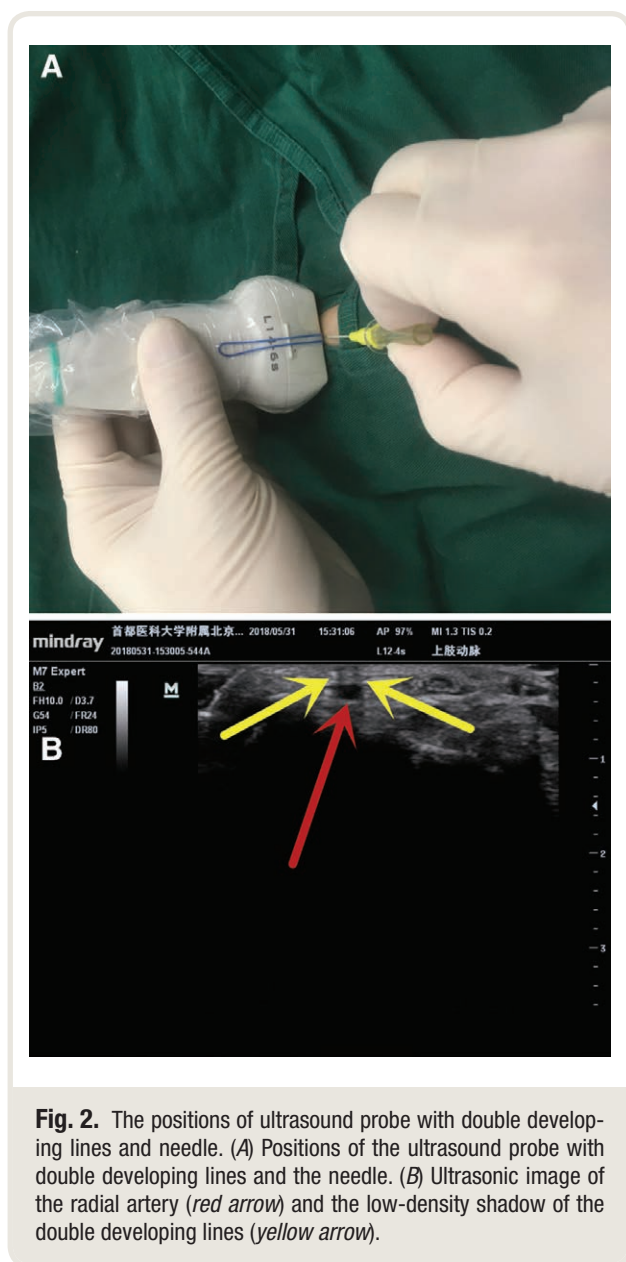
The positions of ultrasound probe with double developing lines and needle. (A) Positions of the ultrasound probe with double developing lines and the needle. (B) Ultrasonic image of the radial artery (red arrow) and the low-density shadow of the double developing lines (yellow arrow).
